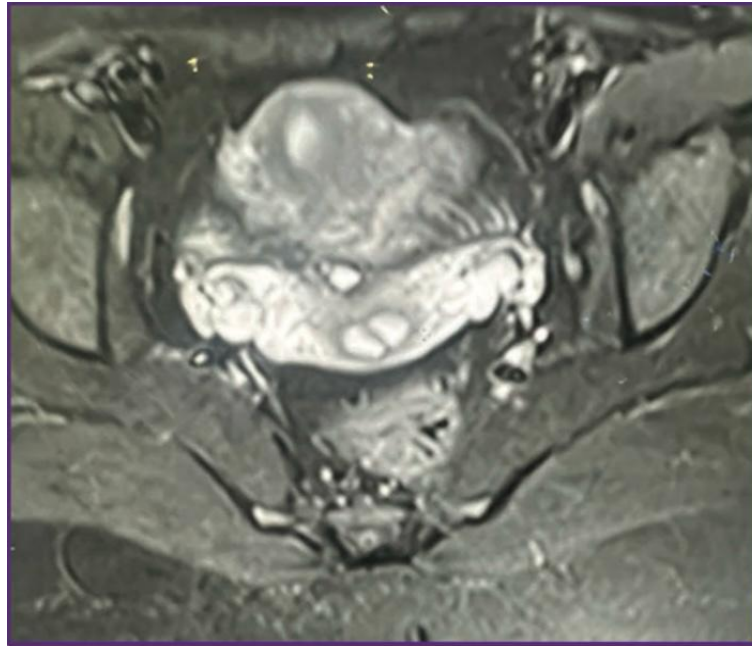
MRI Pelvis shows – septated cervix.
